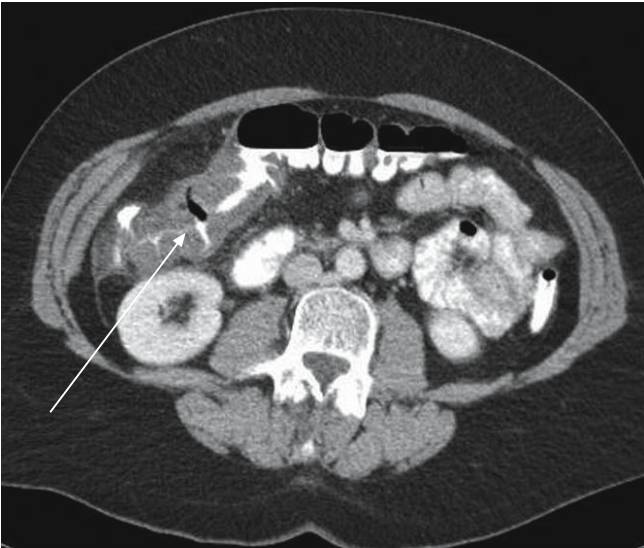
Contrast enhanced CT scan showing thickening of the hepatic flexure of the transverse colon (*arrow*) suggestive of colitis
